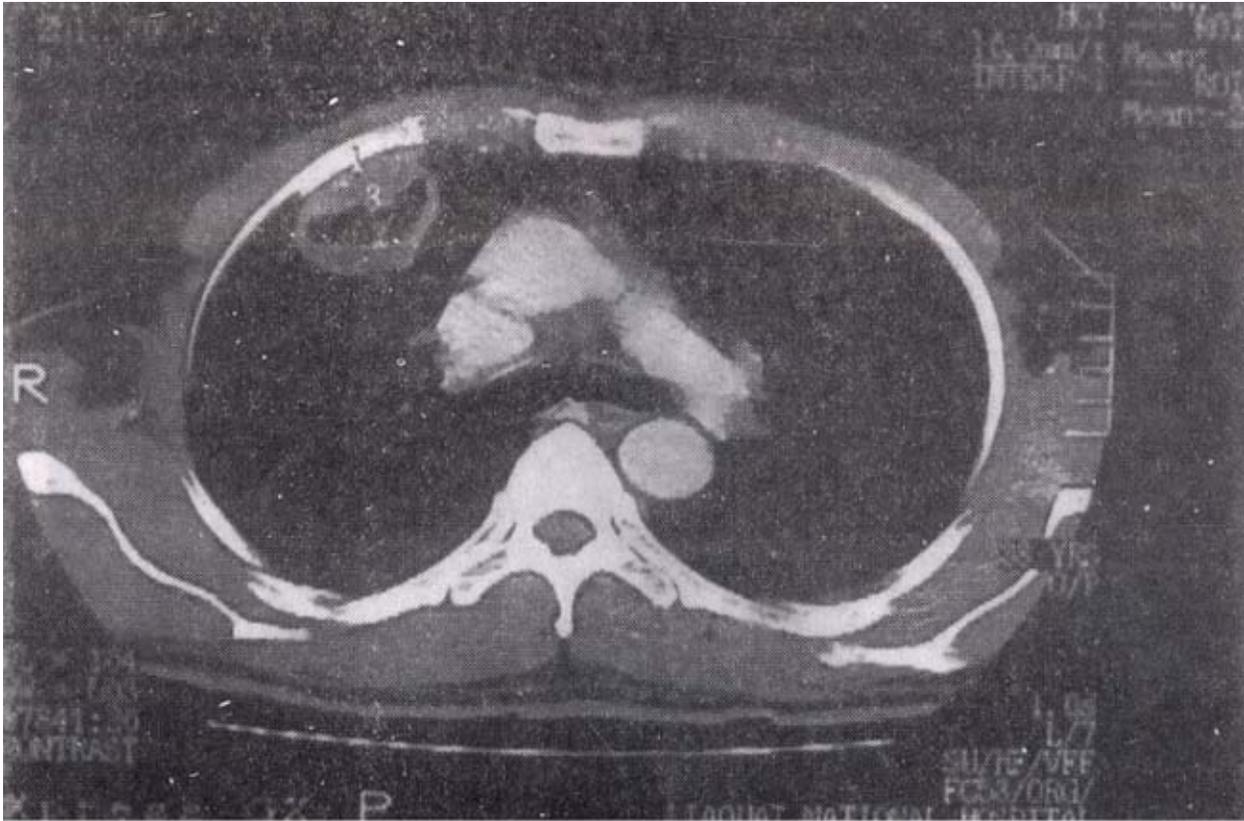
CT scan showing upper lobe cavitary lesion in the anterior segment of right upper lobe.
